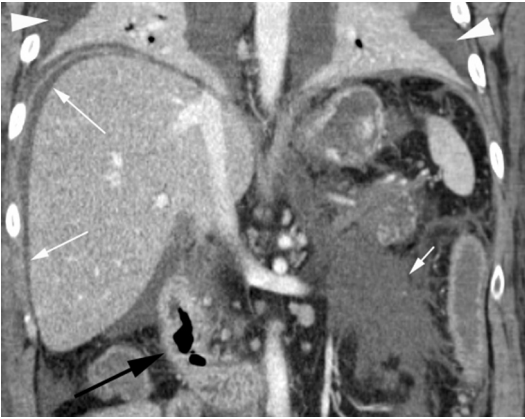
Acute interstitial edematous pancreatitis with ascites and bilateral pleural effusions. The coronal CT image in this 53-year-old woman demonstrates an edematous duodenum (*black arrow*) and retroperitoneal APFC (*short white arrow*). Perihepatic ascites (*long white arrows*) and bilateral pleural effusions (*white arrowheads*) also are noted.
